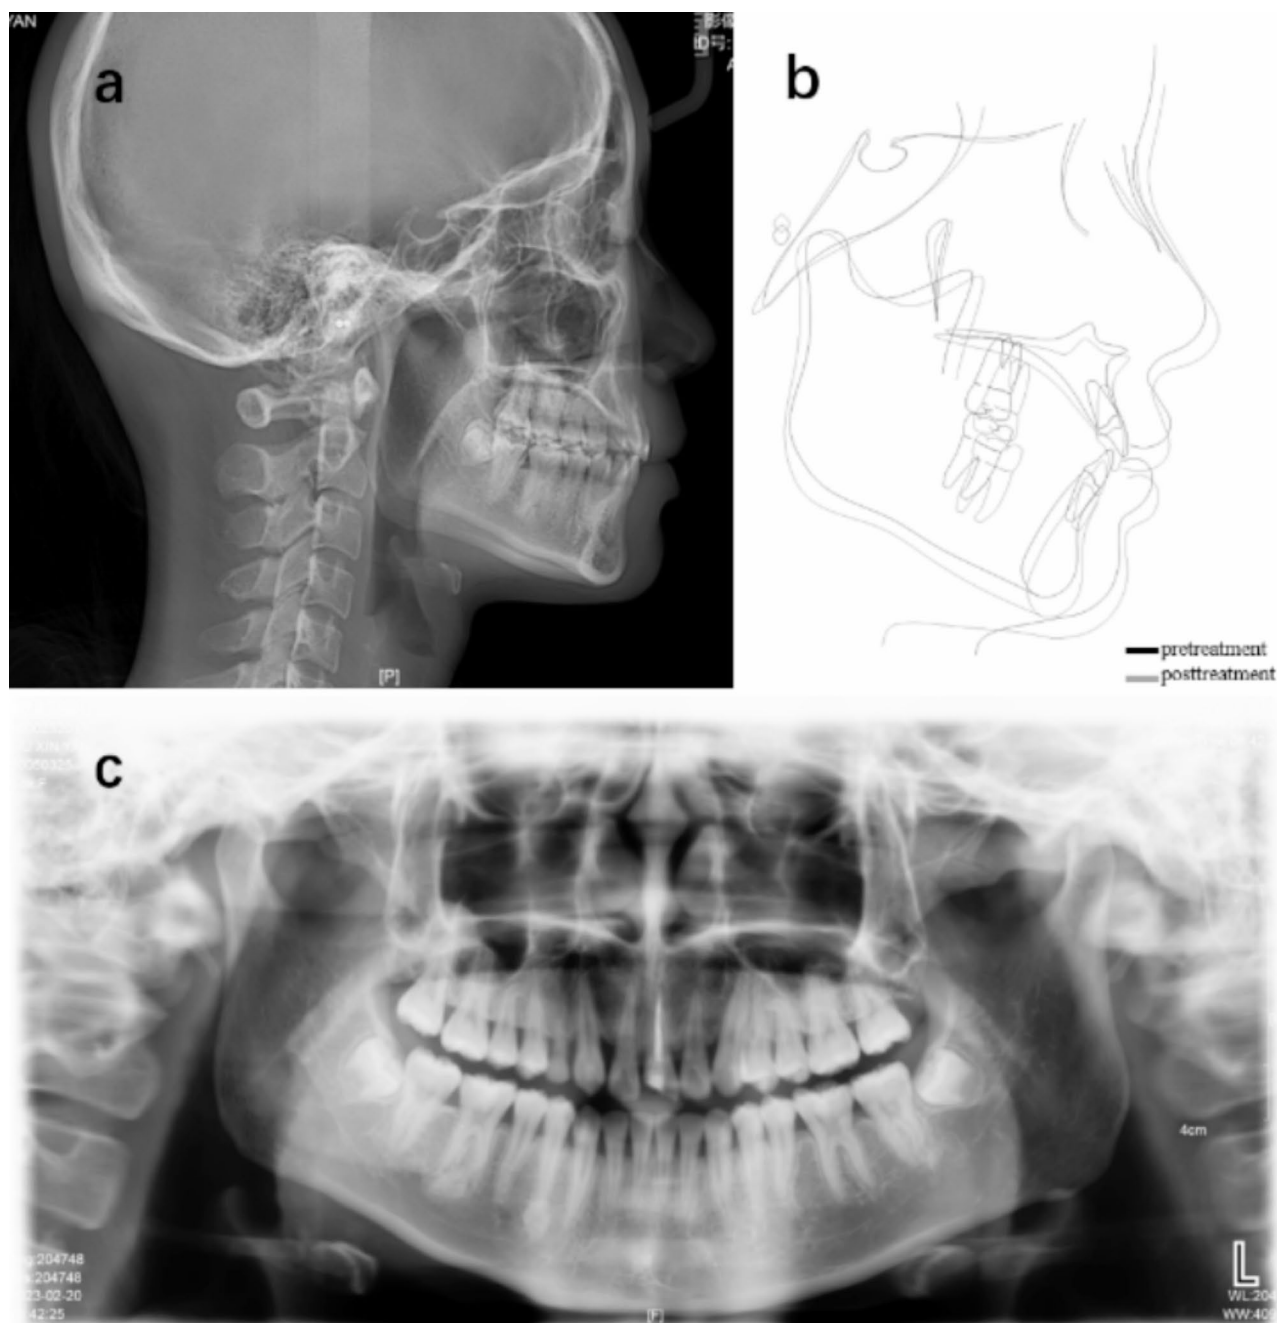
Posttreatment radiographs: a lateral cephalogram. b superimposition of pre- and post-treatment lateral cephalogram. c panoramic radiograph
